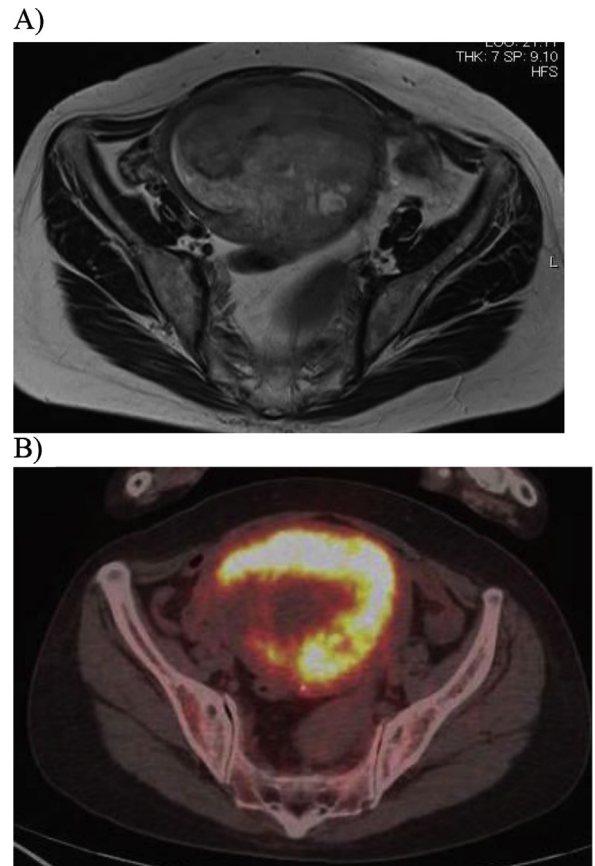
A 70-year-old woman with undifferentiated endometrial sarcoma. (A) On the axial T2-weighted MRI, a high intensity lesion plus low-intensity lesions were noted. (B) An axial PET/CT image showed intense FDG uptake (SUVmax, 19.2).
